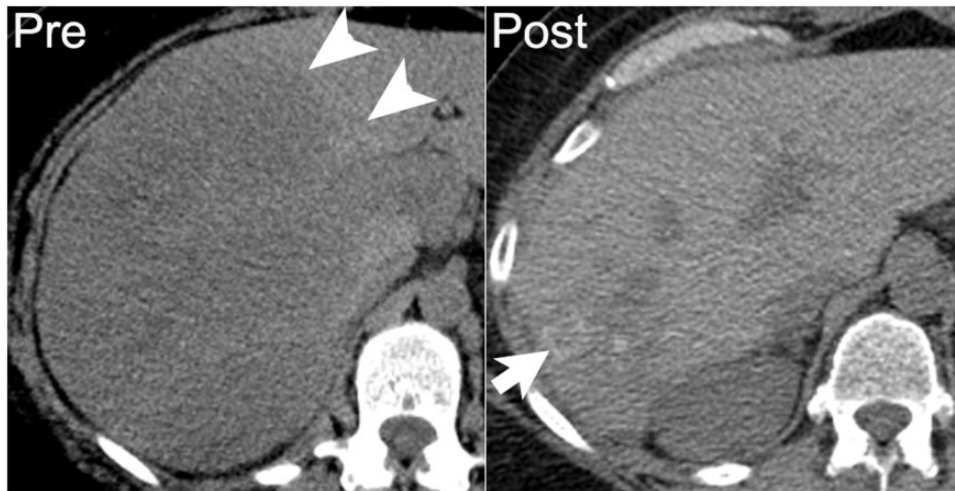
A 52-year-old woman with diffuse large B-cell lymphoma. Axial noncontrast CT image demonstrates large hypodense mass in the right hepatic lobe, which was proved by biopsy to be lymphoma (arrowheads on left). One year later, following chemotherapy and stem cell transplant, the treated hepatic lesion is smaller with amorphous calcification (arrow on right).
